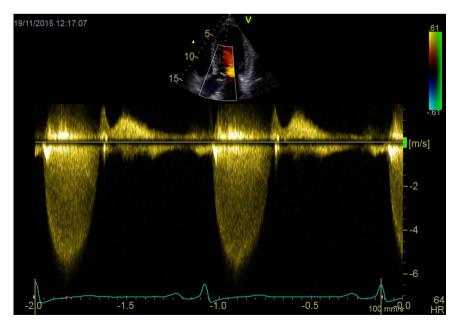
Transthoracic echocardiography. Continuous-wave Doppler recording showing hemodynamically significant fixed subaortic stenosis with peak and mean pressure gradients of 127 mmHg and 87 mmHg, respectively.
